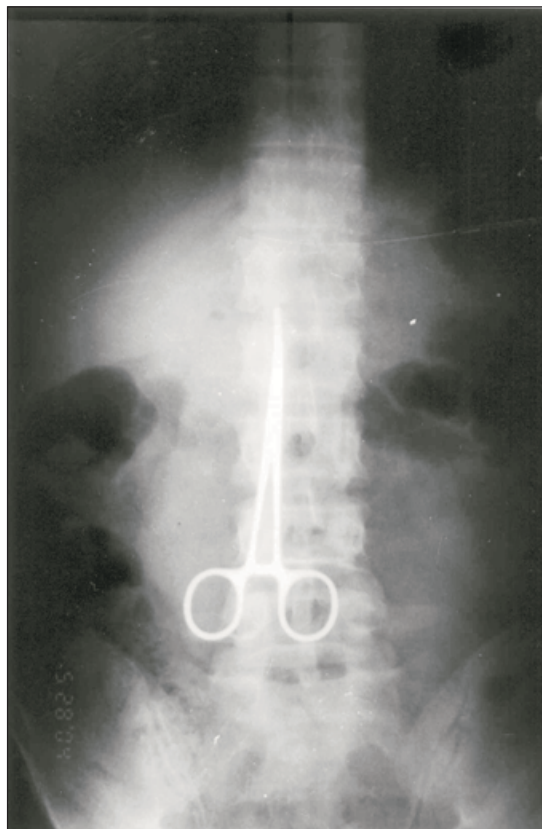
Figure Plain radiograph showing the retained Kocher clamp in abdominal region
